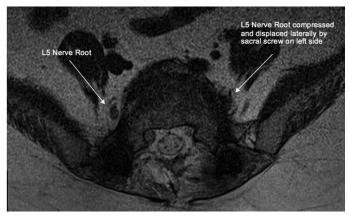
MRI axial cut at the level of S1 pedicle showing impingement and lateral displacement of L5 Nerve root by S1 pedicle screw.
